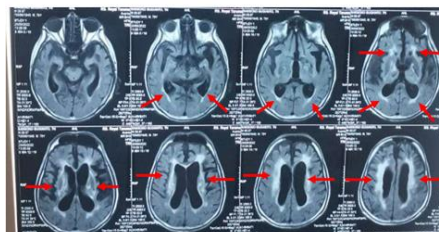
MRI Brain Axial. There is Multiple Chronic Infarct in basal ganglia bilateral, capsula interna genu-crus posterior bilateral, and lacunar infarct on the left
